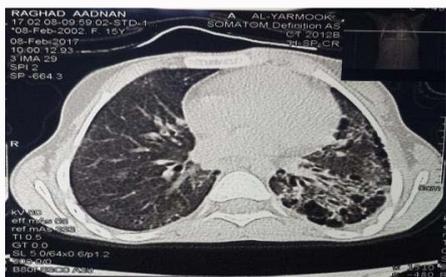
HRCT of the patient showing Ground Glass opacities with honeycombing and traction Bronchiectasis.
